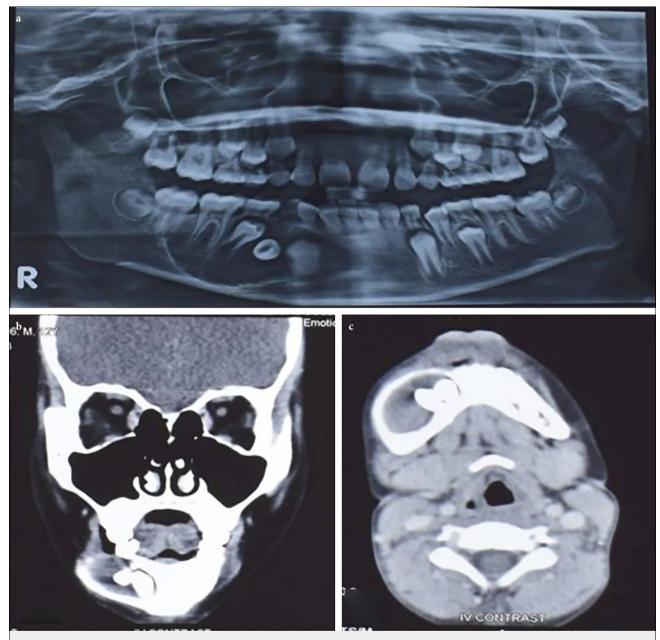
Pre-operative radiographic images showing the characteristic features of the large dentigerous cyst in right body of mandible: OPG radiograph (a), contrast-enhanced CT-scan radiograph (b, c)
